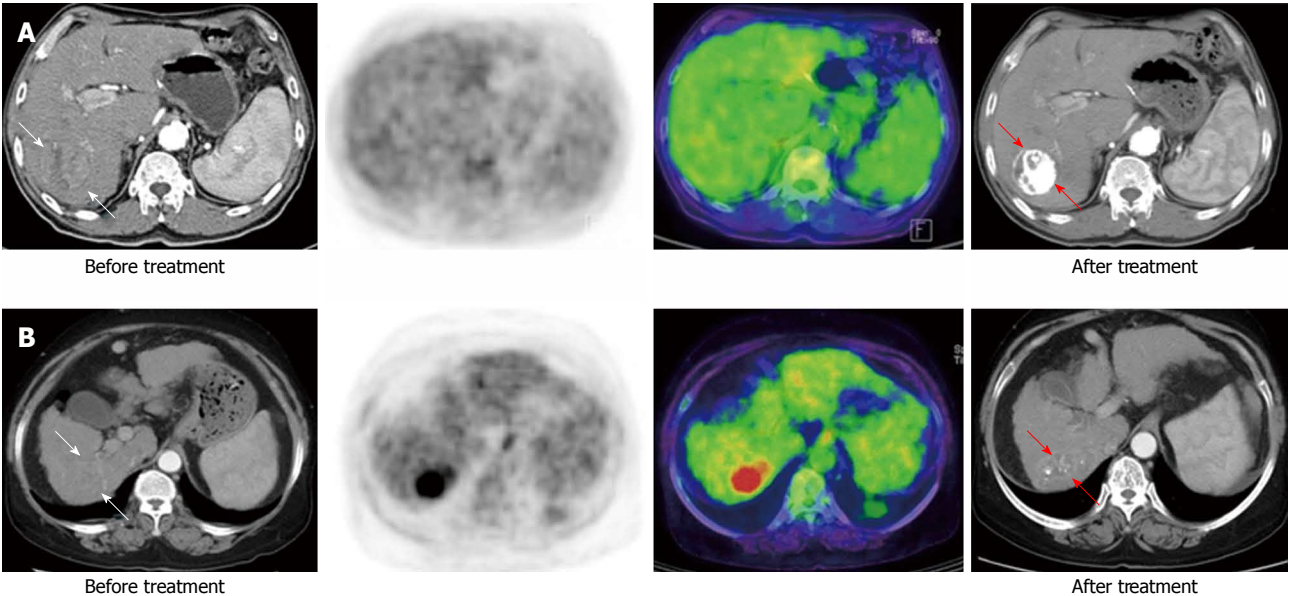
Baseline and follow-up images after treatment of fluorodeoxyglucose uptake according to the $Tsuv_{max}/Lsuv_{mean}$ ratio. A: Patient with nodular hepatocellular carcinoma (HCC) (white arrow) based on liver dynamic computed tomography (CT) showed fluorodeoxyglucose (FDG) uptake with a low $Tsuv_{max}/Lsuv_{mean}$ ratio (< 1.90) in ^{18}F -FDG positron emission tomography/CT. After transarterial chemo embolization, this patient showed compact lipiodol uptake (red arrow) on follow-up liver CT; B: Patient with infiltrative type HCC (white arrow) in liver dynamic CT showed FDG uptake with a high $Tsuv_{max}/Lsuv_{mean}$ ratio (≥ 1.90). This patient showed faint lipiodol uptake (red arrow) in a follow-up liver CT. The patient with a low standardized uptake value (SUV) ratio showed improved treatment response and survival over the patient with a high SUV ratio (complete response vs stable disease, 782 d vs 167 d, respectively).
